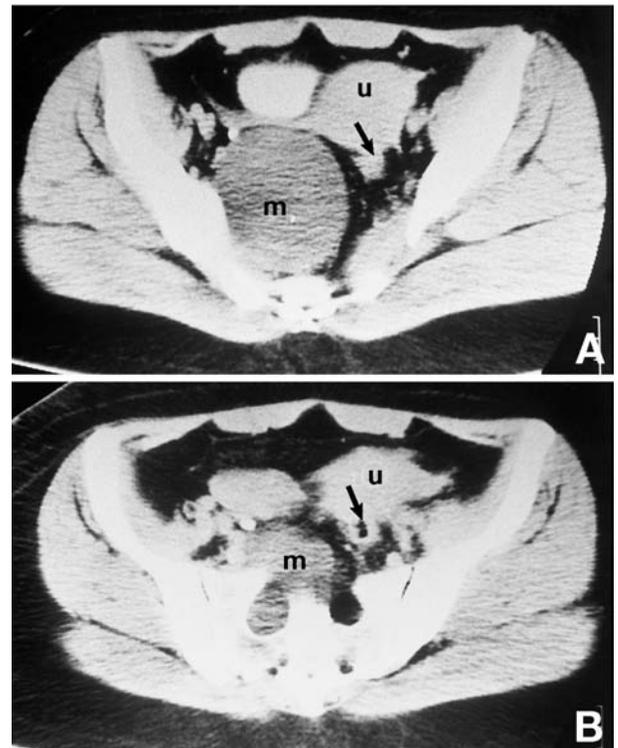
A: Axial computed tomography (CT) scan showing a smooth-contoured hypodense mass lesion (m) which had displaced the uterus (u) and rectum (arrow) to the left. B: Axial CT scan displaying the enlarged right sacral foramina, containing soft tissue, isodense with the mass. The fat plane was obliterated between the foramen and the mass.
